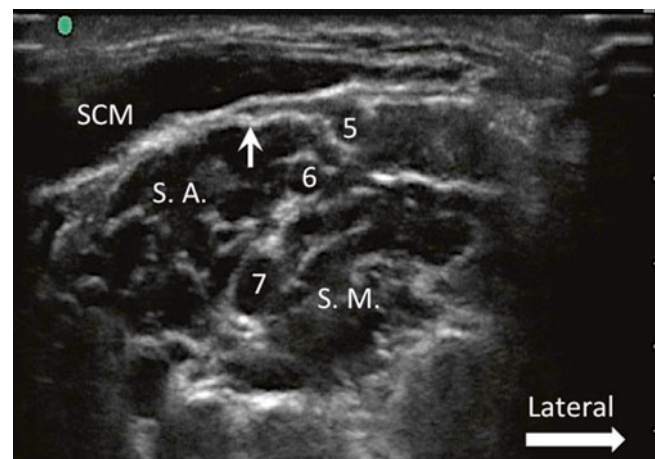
Sonography of the phrenic nerve. The nerve is small and is usually hypoechoic (*arrow*). *SCM* sternocleidomastoid muscle, *SA* scalenus anterior muscle, *SM* scalenus medius muscle. Cervical nerve roots 5–7 are numbered accordingly as 5–7 (Reproduced with permission from Philip Peng Educational Series)
